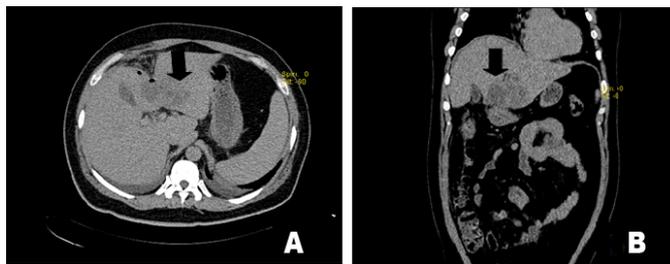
(A,B): Contrast enhanced CT scan showing low density area (black arrows) with gas and fluid, measuring approximately 7.5x 8cm consistent with left-sided intra-hepatic abscess (A: axial plane, B: coronal plane).
